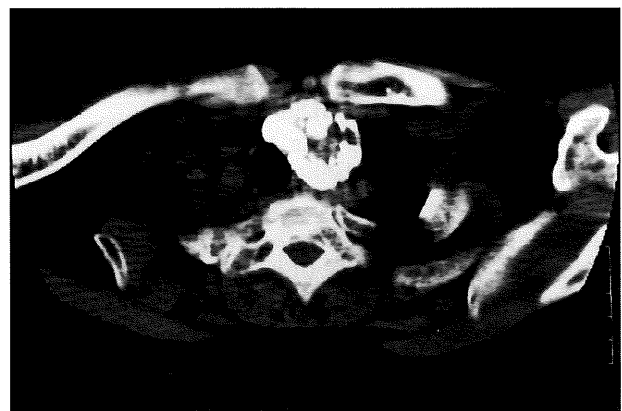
Computed tomography of the chest showed that the mass was attached to the trachea.
